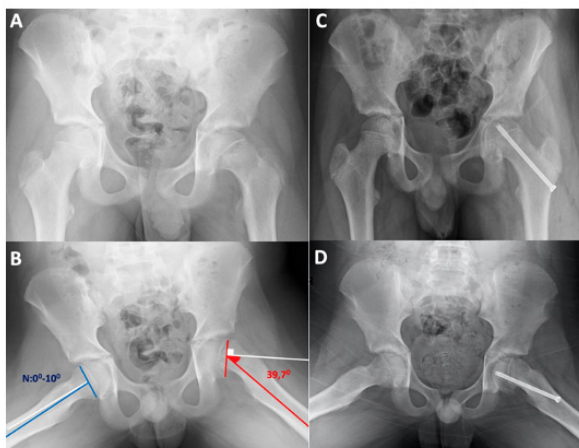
Slipped capital femoral epiphysis on the left hip in a 14 years old girl. A; Preoperative Anterior/Posterior pelvis X-ray. B; Preoperative lateral hip x-rays. Left side Southwick angle measurement is 39,70 degree. Right side is normal. C; Postoperative 6th month Anterior/Posterior x-ray view and D; lateral view.
